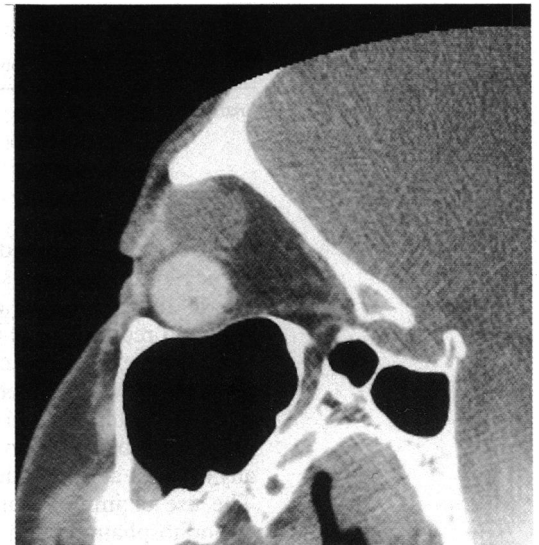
Sagittal CT scan of the anophthalmic orbit (patient 3). A large conjunctival cyst superior to the implant is present. The implant is displaced downwards.
